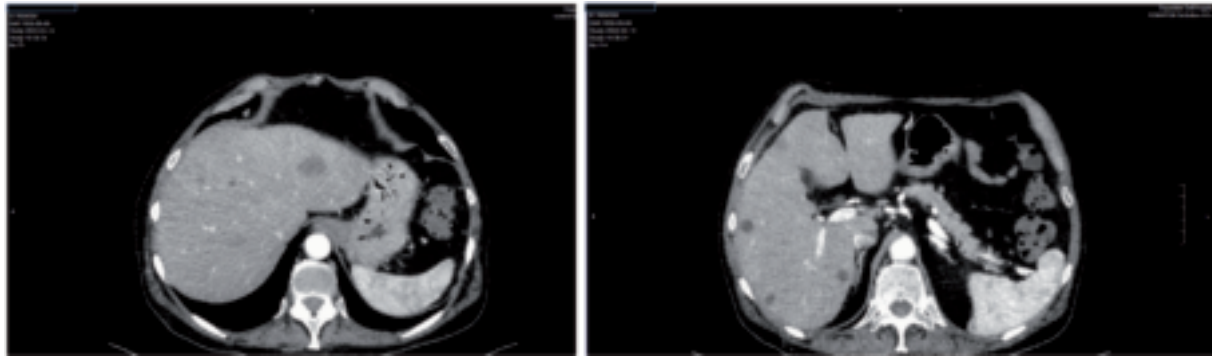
Computed tomography of the abdomen with and without medium contrast. In both hepatic lobes, multiple nodular formations are observed. Such formations result from hypodense in all dynamic phases and have internal septa, more numerous and thicker for the major formations, with enhancement after contrast.
